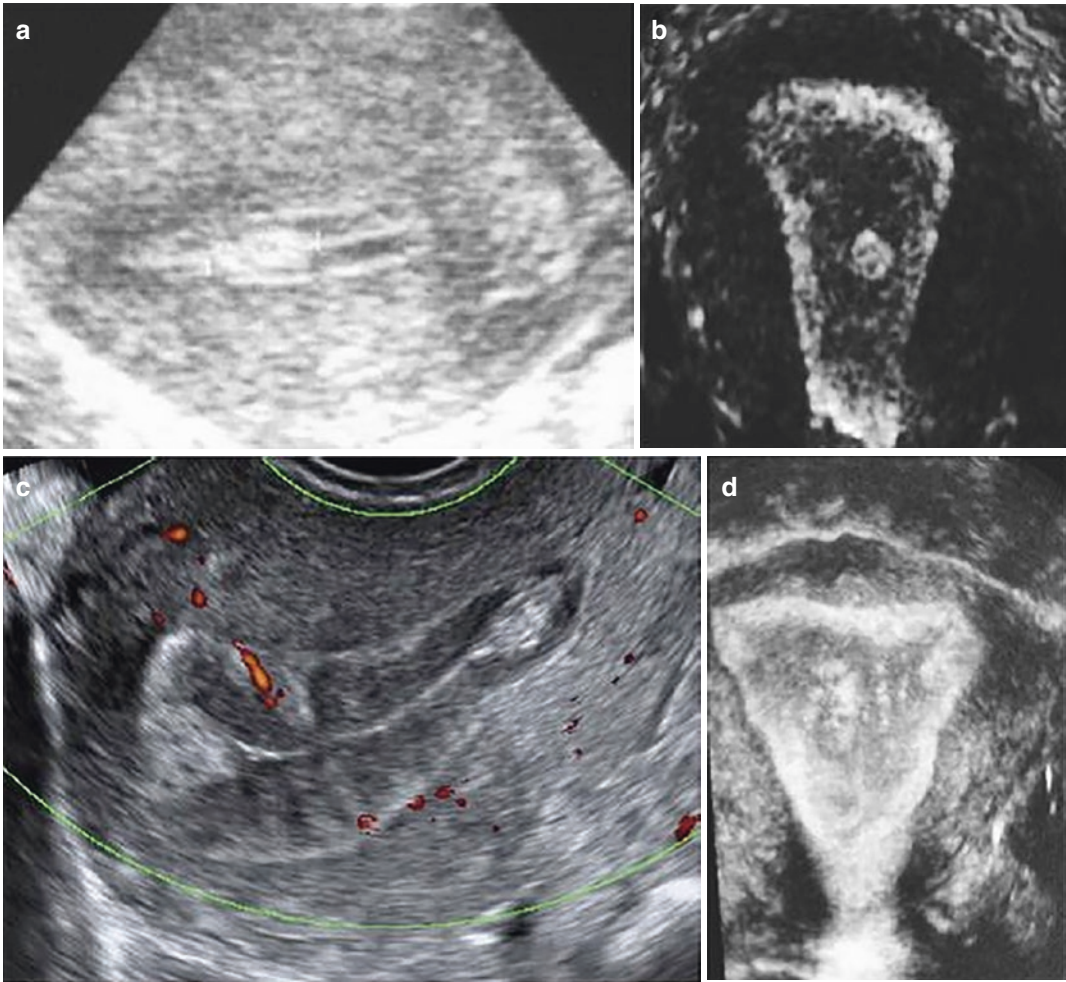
Endometrial polyps. A single polyp located in a lateral wall at midcorpus, shown in two-dimensional transvaginal ultrasonographic view (a) and in 3D imaging
